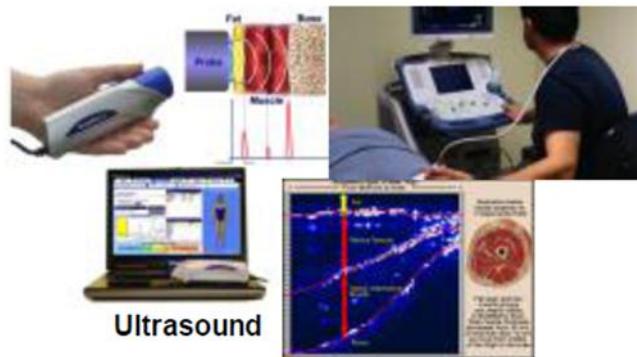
explain ultrasound device diagnosis body composition.
